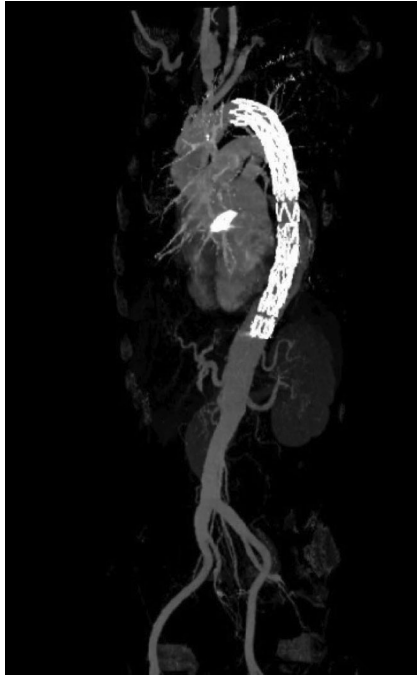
Computed tomography imaging after the second surgery.
